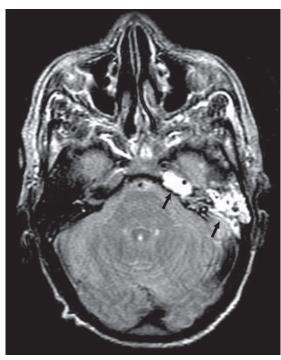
Axial T2-weighted MRI showing left mastoiditis and petrous apicitis (arrows) as high signal in mastoid and petrous apex. (From Budenz CL, El-Kashlan HK. Complications of temporal bone infections. In: Flint PW, Francis HW, Haughey BH, et al, eds. Cummings Otolaryngology Head & Neck Surgery, 7th ed., vol. 2. Philadelphia: Elsevier; 2021: Fig 141.17A.)
